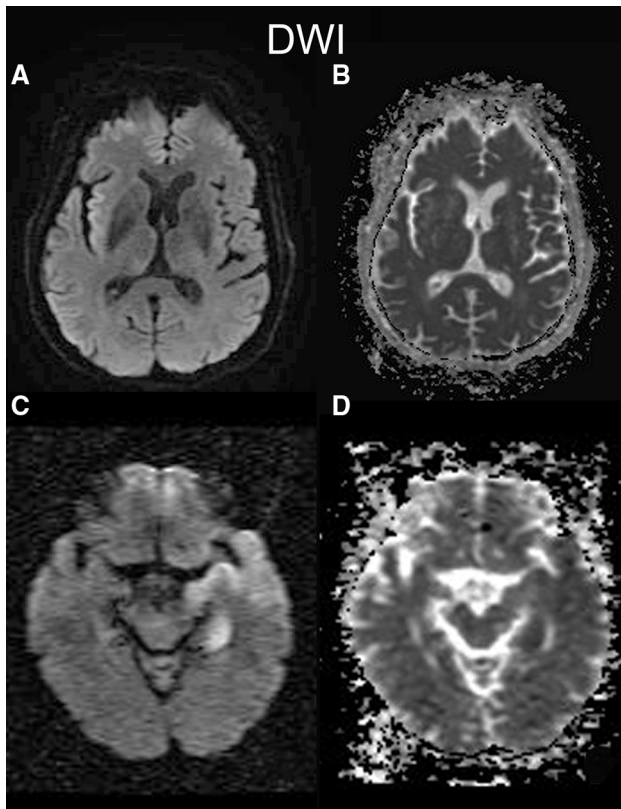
Examples of two cases of HSV-1 encephalitis (a–b and c–d) with areas of restricted diffusion on diffusion-weighted imaging (DWI) sequence. a DWI abnormality affecting the right insular cortex. b Corresponding changes on the apparent diffusion coefficient (ADC) map. c DWI abnormality on the left temporal lobe. d Corresponding changes on the ADC map
